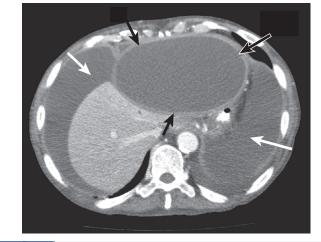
On computed tomography, a large pseudocyst is seen (black arrows). In addition, ascites surrounding the liver (white arrow) is caused by a leak from the pseudocyst (pancreatic ascites).
